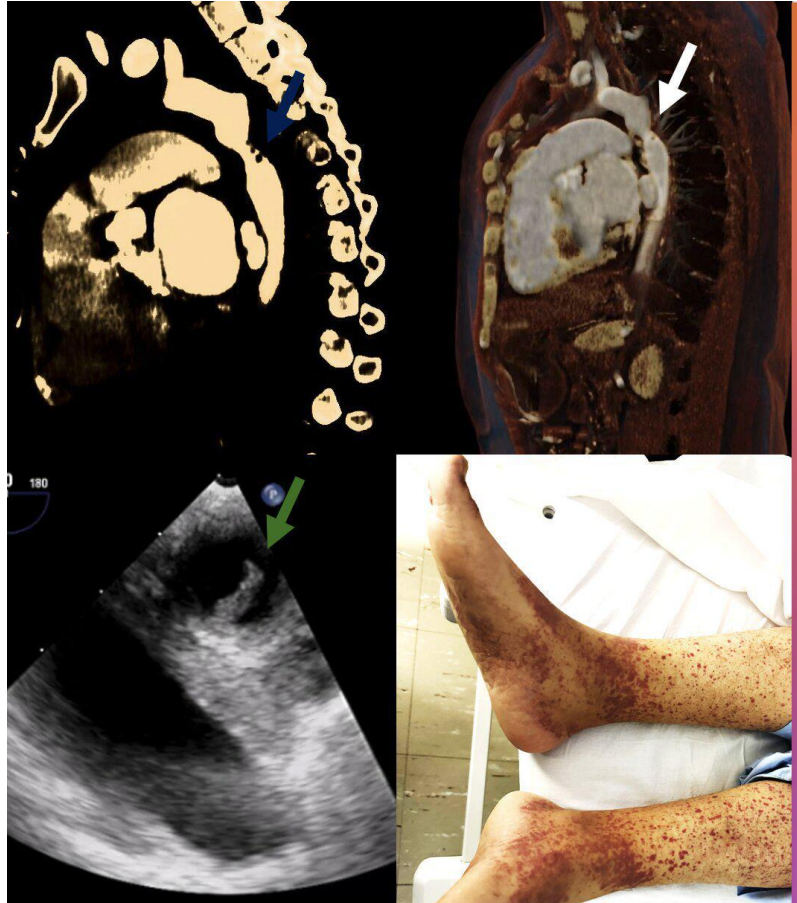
(A) CT scan, sagittal view, displaying the aortic coarctation and aortic vegetations (blue arrow). (B) CT scan, 3D reconstruction, showing CoA (white arrow). (C) Transesophageal echocardiogram (ETE), axial view showing vegetation adhered to the wall of the descending aorta (green arrow). (D) View of pigmented purpuric macules coalescing into purpuring plaques on lower extremities.
